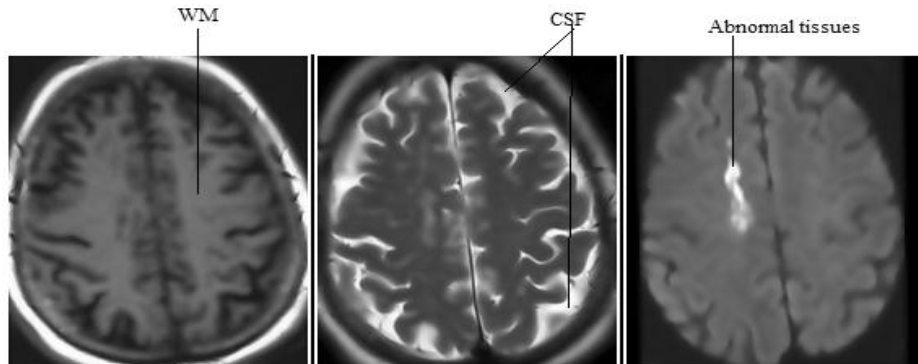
Input Slices of T1WI, T2WI and DWI (from left to right)
